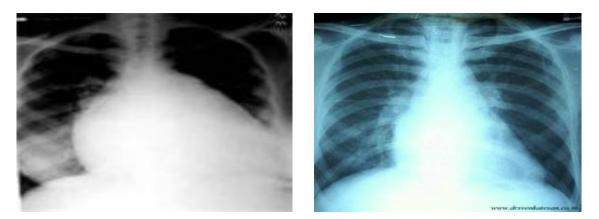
Chest X-ray heart enlarge
